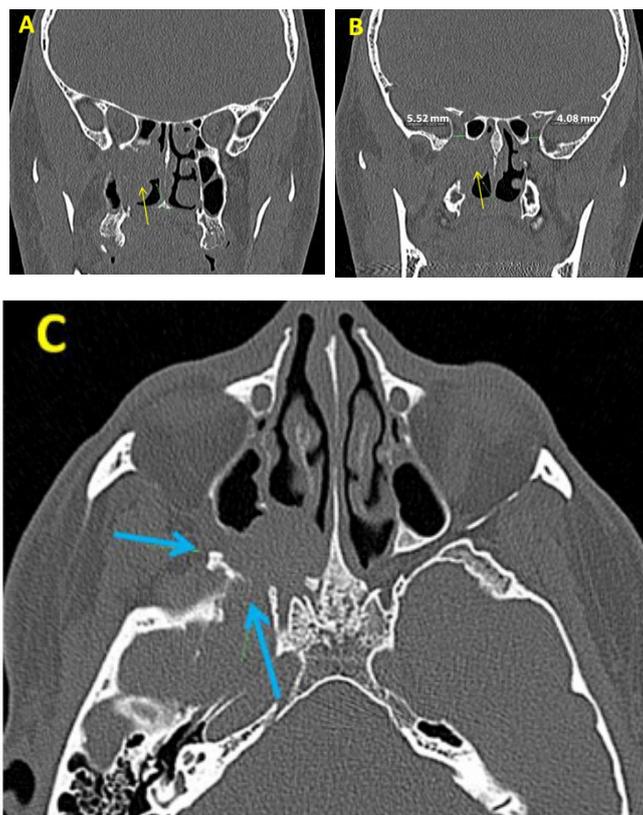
Coronal (A and B) and axial (C) CT scan showing Tumor process (A, B, thin arrow) centered on the right pterygo-palatal fossa with extension to the nasal cavity responsible for enlargement of the superior orbital fissura (B, fine line) measured at 5.52 mm in the right side Vs 4.08 mm in the left one) as well as the base of the skull (C).
